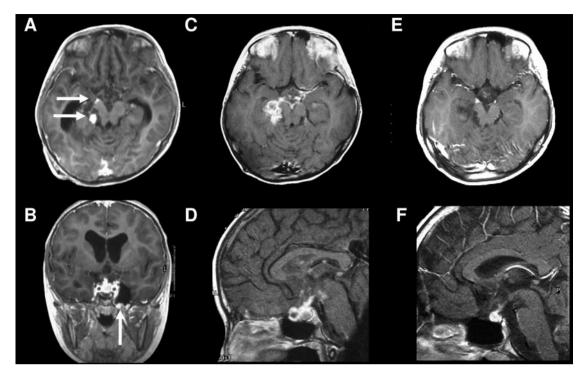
Case 3. Gadolinium-enhanced brain MR images (A and B) show small enhanced lesions in the suprasellar region, an ambient cistern (arrow), and a left arachnoid cyst (arrow). Gadolinium-enhanced axial (C) and sagittal (D) brain MR images after three courses of the first treatment (cisplatin, ifosfamide, etoposide) show enlargement of enhanced lesions. Gadolinium-enhanced axial (E) and sagittal (F) brain MR images after six courses of the second treatment (cisplatin, vincristine, ranimustine) show remarkably reduced tumor enhancements.
